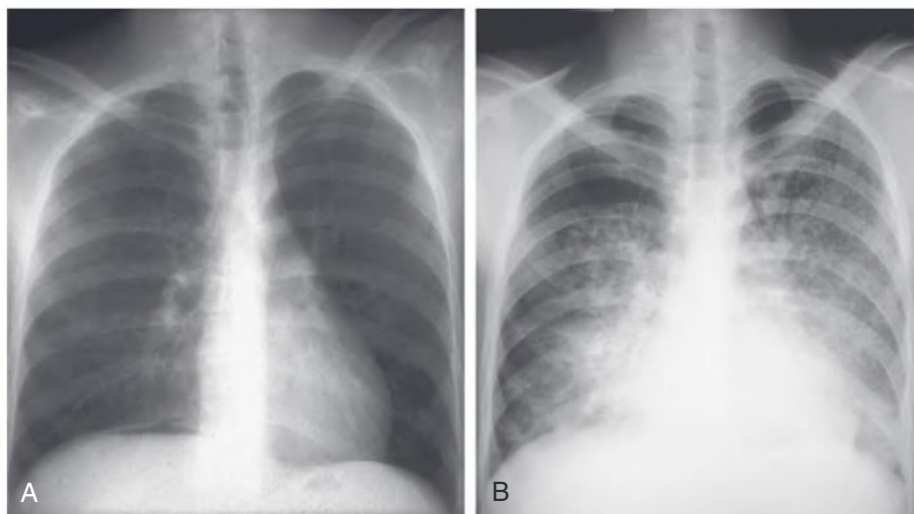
Lung Hemorrhage. (A) Patient with early pulmonary hemorrhage. The chest radiograph still appears normal. (B) Radiograph taken 4 days later shows the evolution of alveolar shadowing caused by lung hemorrhage.
